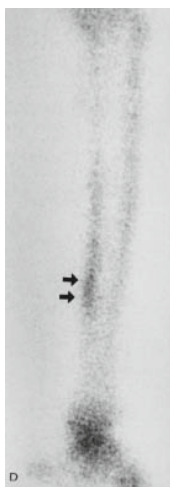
Bone scintigraphy showing abnormal longitudinal uptake in lateral view [3].
